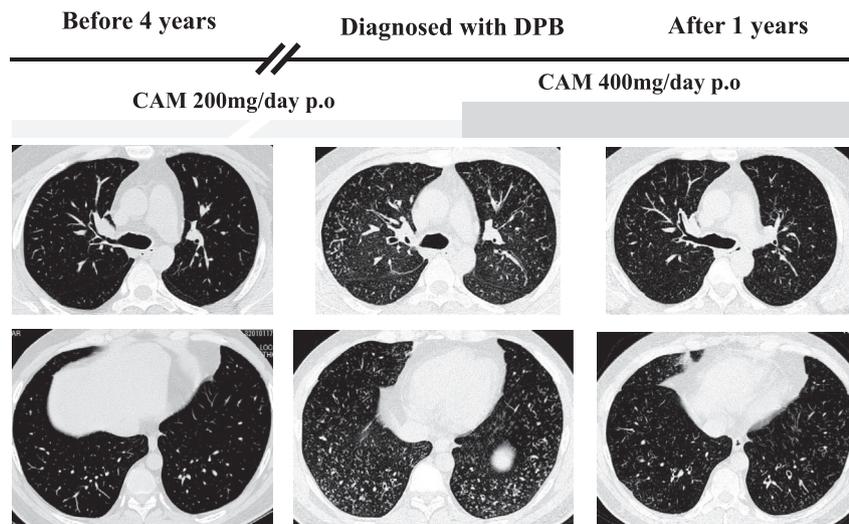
Chest HRCT findings. At 4-years prior to the diagnosis with DPB, chest HRCT demonstrated normal findings. At the diagnosis, it demonstrated bilateral diffuse centrilobular granular shadows and bronchial wall thickenings. After 1-year treatment by switching to long-term treatment with normal-dose CAM, these abnormal findings decreased.
